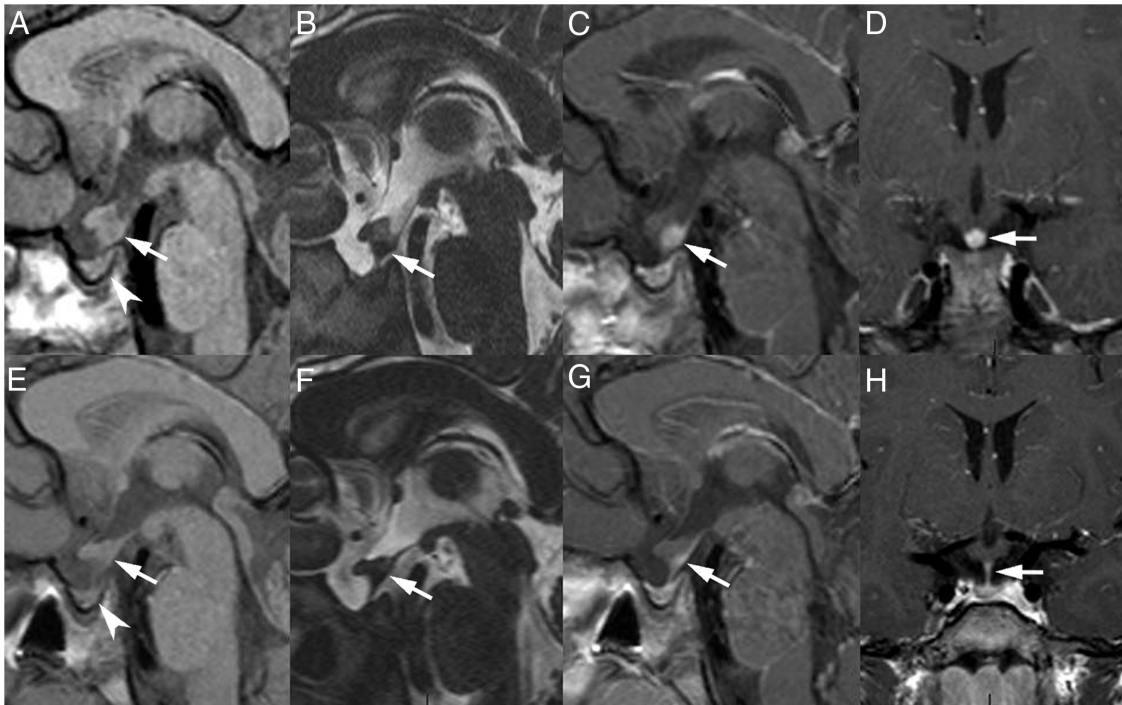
MRI follow-up of a patient with inflammatory pituitary stalk thickness. A–D, sagittal T1-weighted image (A); sagittal T2 DRIVE image (B); and sagittal (C) and coronal (D) postcontrast T1-weighted images at presentation. There is an absence of the posterior pituitary bright spot (arrowhead, A) and thickening of the infundibulum (arrows, A and B), which enhances after contrast material administration (arrows, C and D). E–H, sagittal T1-weighted image (E), sagittal T2 DRIVE image (F), and sagittal (G) and coronal (H) postcontrast T1-weighted images after 2 years. The posterior pituitary bright spot is still undiscernible (arrowhead, E); however, the infundibulum has normalized (arrows, E–H).
